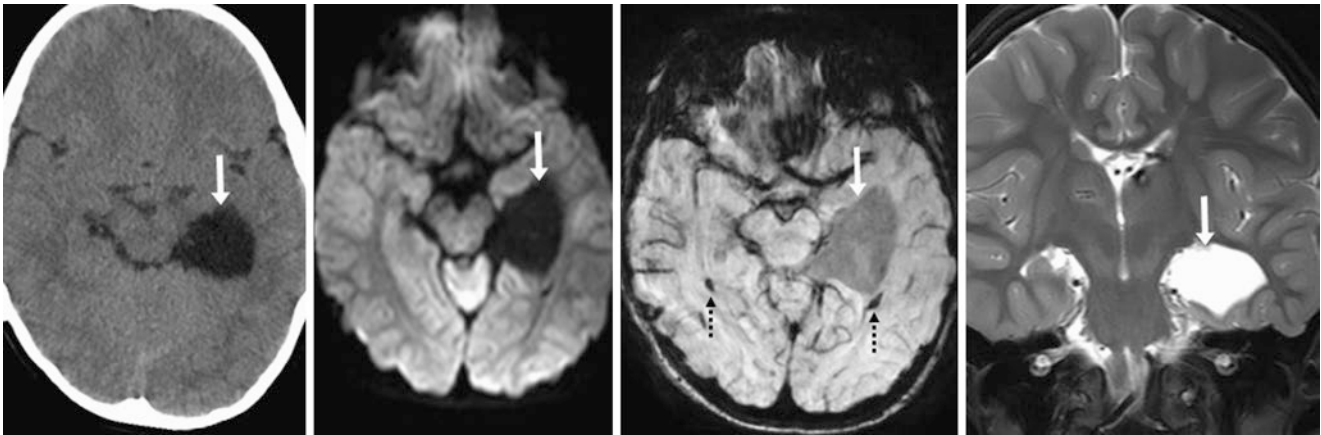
Comparison case of a large choroid fissure cyst. A 7 year old with a remote perinatal insult had left choroidal fissure enlargement from a 3.5-cm cyst (arrows), without hydrocephalus, on NECT (left). The cyst had a CSF-like signal on DWI (left middle), FLAIR (not shown), SWI (right
